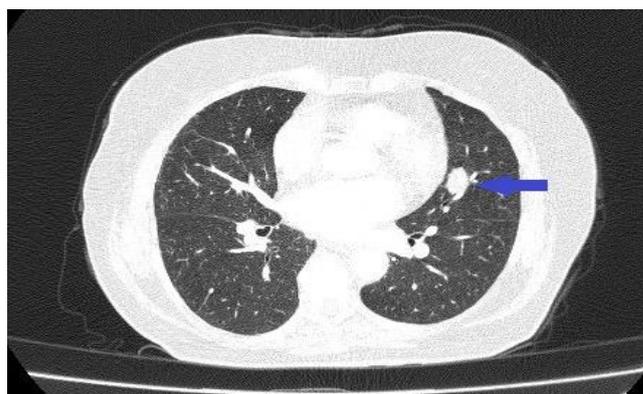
Thorax computed tomography showing a 15x20 mm nodule in left lung lingual lobe
